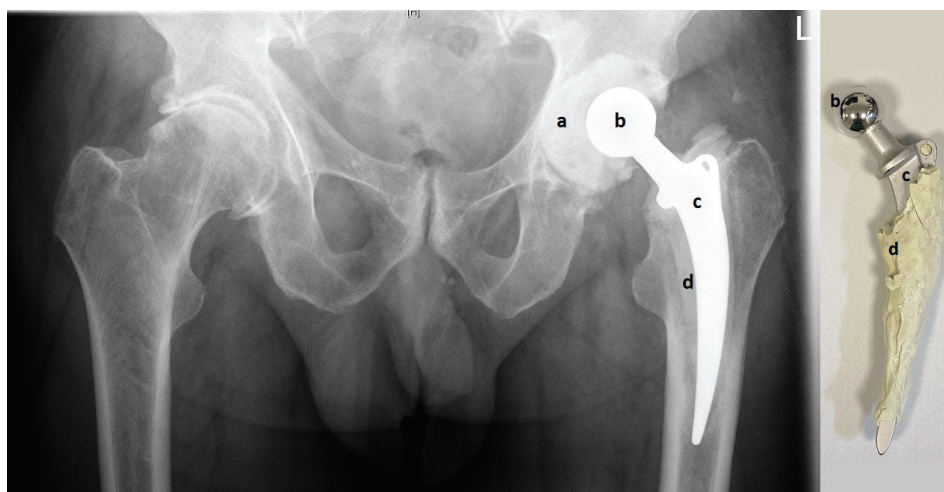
Pelvic X-ray with articulating spacer in situ (left) and the same spacer after explantation (right). The custom-made acetabular socket (a) is made of antibiotic-loaded PMMA (polymethylmethacrylate) bone cement and creates the metal-on-cement articulation with the CoCr femoral head (b). PMMA bone cement (d) is also used to fix the femoral stem into the femur (c).
